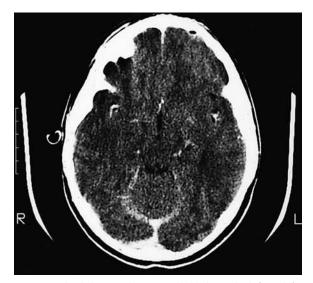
Epidural abscess. This patient had lethargy, high fever, left eye pain, and periorbital swelling after 1 week of severe nasal congestion. A CT scan, obtained to rule out orbital involvement, revealed a small epidural abscess behind the left frontal bone. Note the small central air pocket.
